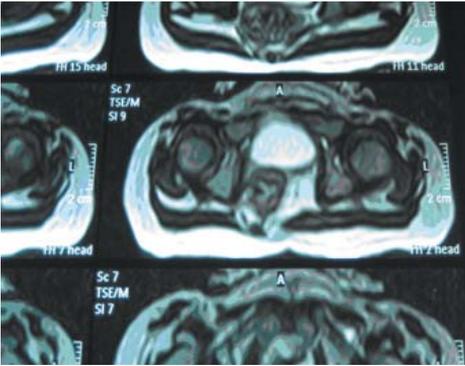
MRI pelvis shows right deviation of anorectal canal and absent image of both ovaries.
